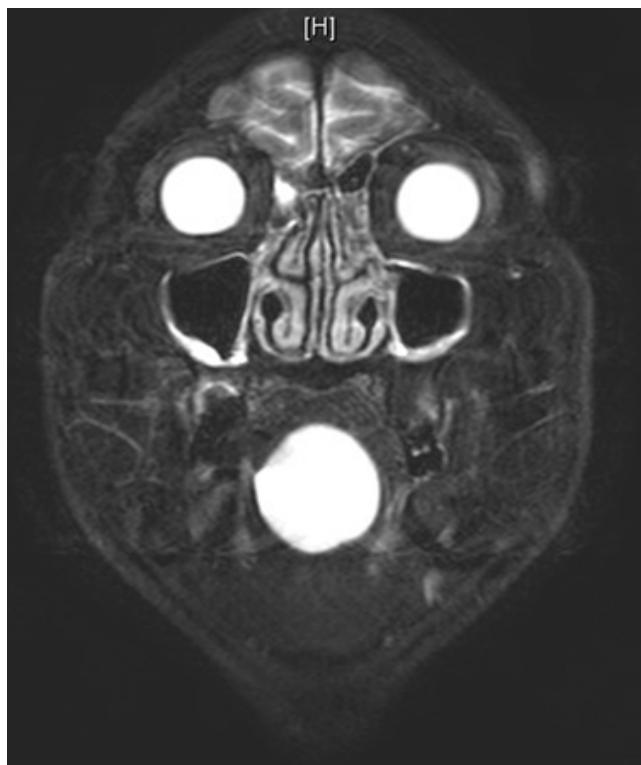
Magnetic resonance image (MRI) in coronal view (T2-weighted)
